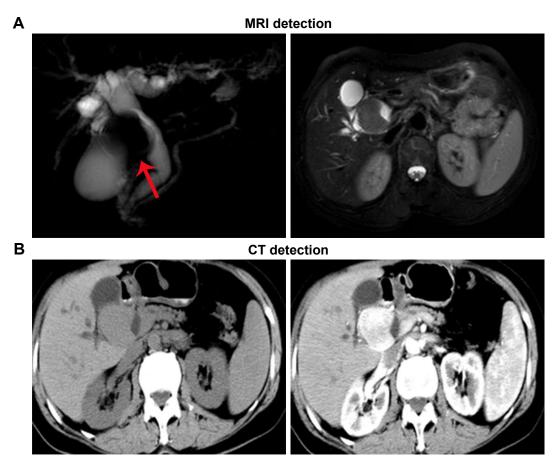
Figure I Preoperative MRCP, MRI, and CT detection.
